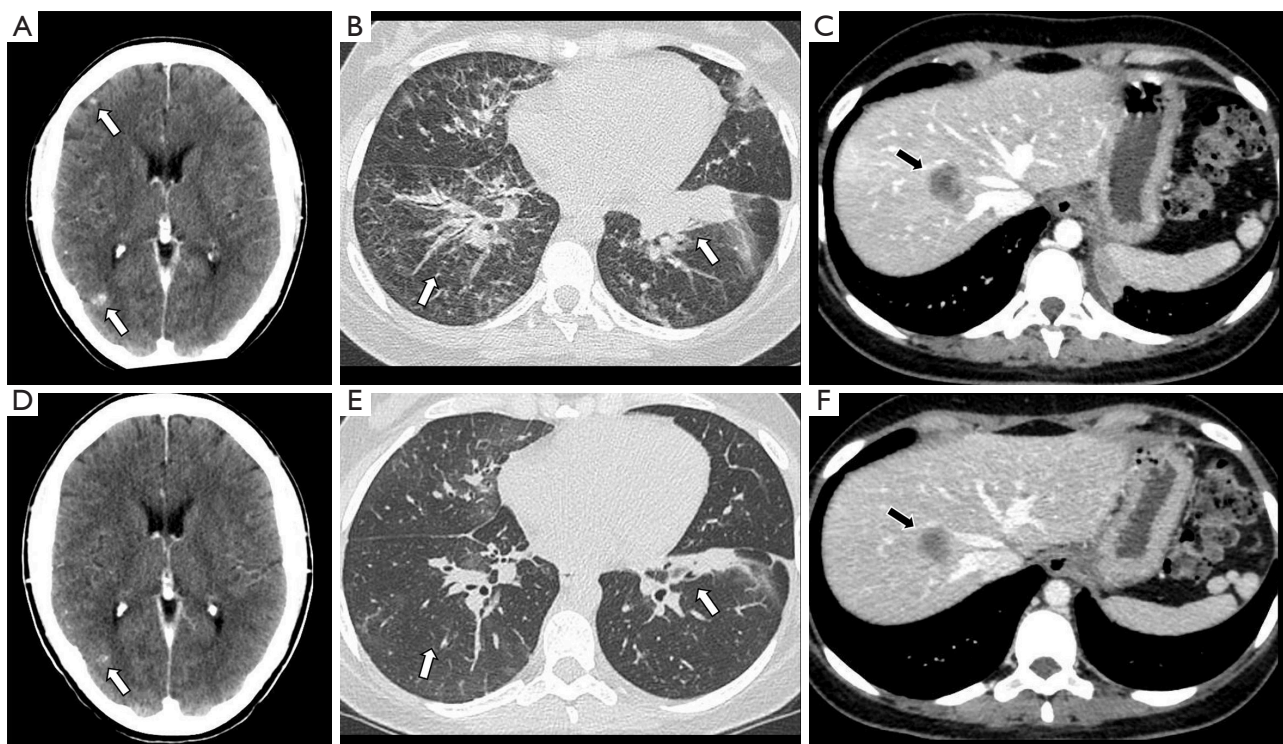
CT scans of case #1 performed before the initiation of the therapy with erlotinib (A-C) and after three weeks of treatment (D-F), showing PR on brain, lungs and liver lesions, see arrows. CT, computed tomography; PR, partial response.
